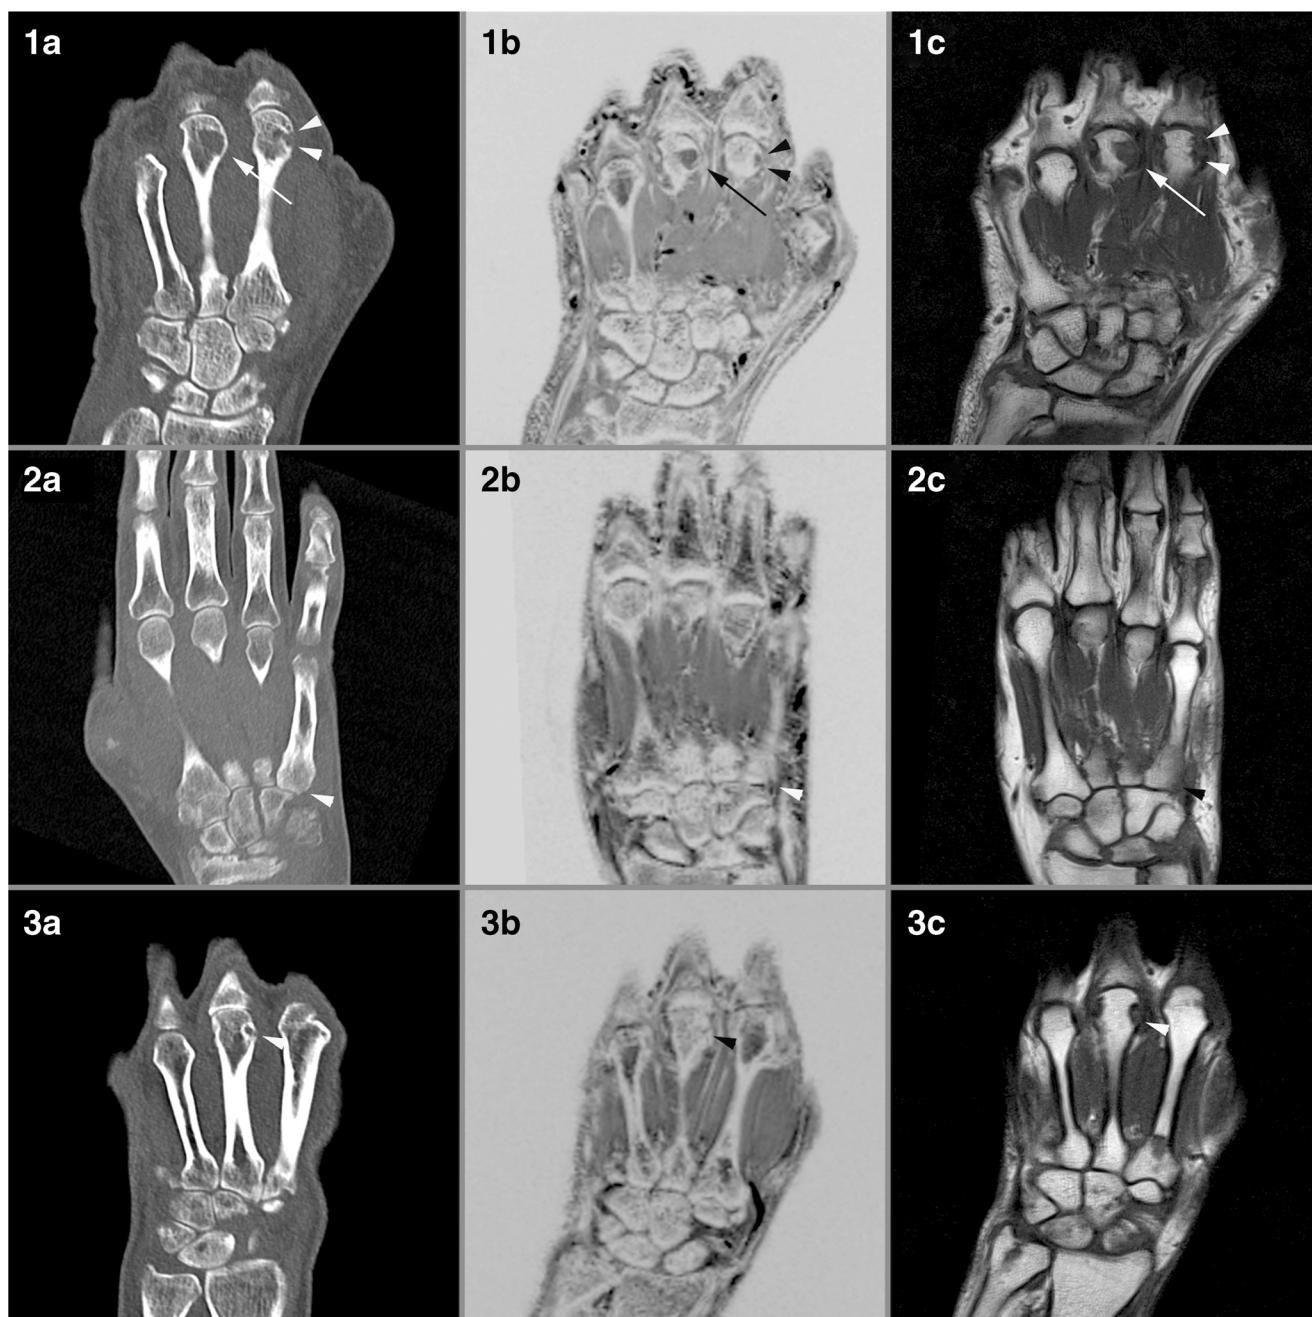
Examples of imaging findings in study patients. a CT; b Inverted susceptibility-weighted MRI (SWI); c T1-weighted MRI (T1w); 1: 67-year-old man with seropositive rheumatoid arthritis. In CT, erosions were detected i.a. in the head of metacarpal bone II, which was also visible in SWI and T1w (*arrowheads*). CT and SWI detected a bone cyst (without cortical break) in the head of metacarpal bone III. However, on T1w, the cyst was misinterpreted as an erosion in the third metacarpal head
